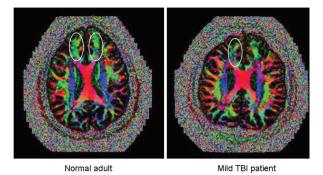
Magnetic resonance imaging-diffusion tensor imaging images in a normal control individual and a mild traumatic brain injury (TBI) patient. The patient shows reduced white matter integrity in the right anterior corona radiata (ACR) shown by the circled region, compared to the normal individual's circled left and right ACR. Courtesy of Niogi S, Weill Medical College of Cornell University.
